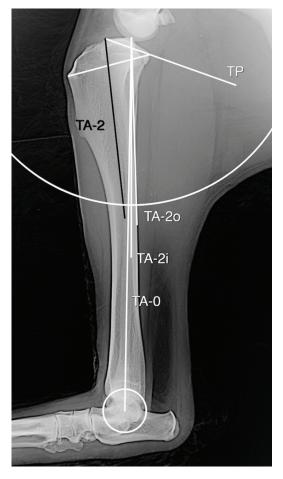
Mediolateral radiograph of the tibia and tarsal joint showing all tibial axes used in this study and their relation. The abbreviation used for the axes are the same as those used for the measuring methods
